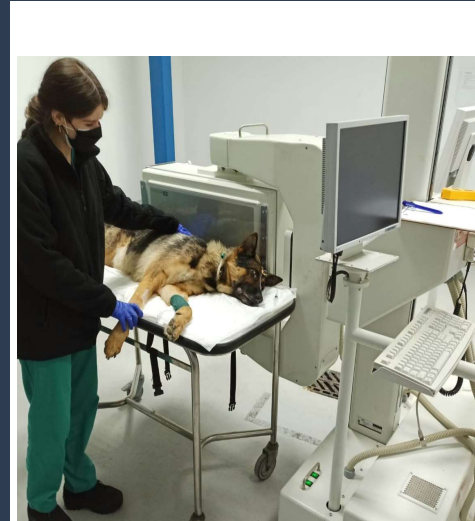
Preparation of a five years old patient before scintigraphy.
